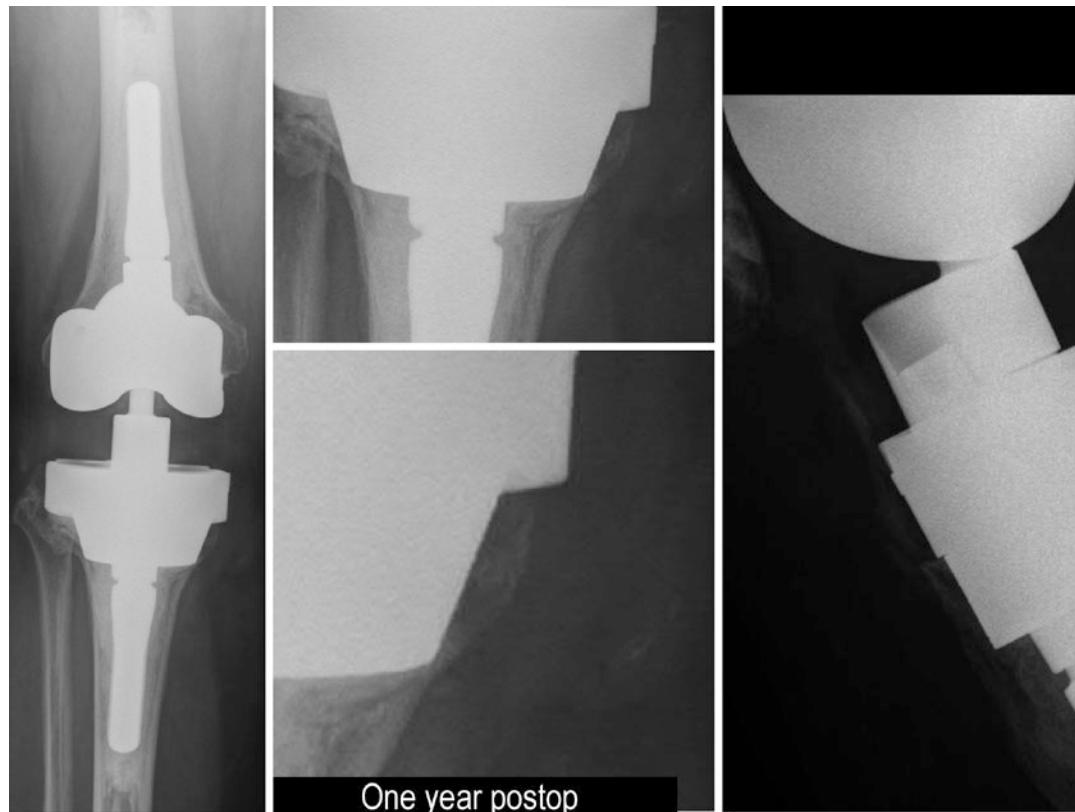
Radiographs at 1 year post surgery with excellent fixation and no lucencies at the interfaces of bone and implant or cement. Note that bone graft material is still visible but appears less dense than previously
